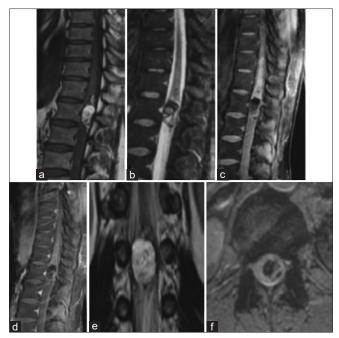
Spinal magnetic resonance imaging: Teratoma of the medullary conus. Sagittal section on T1 sequence (a), STIR sequence (b), T1 fat sat before (c) after gadolinium enhancement (d); Coronal section on T2 sequence (e); Axial section on gradient echo (f): a tumoral process with triple component, one tissular with nodular enhancement, one apical with lipidic consistence, and a third that is hemorrhagic
